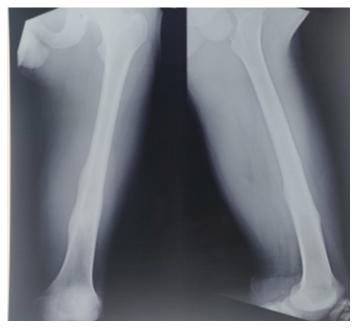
Six weeks follow-up radiograph showing thickening of periosteal reaction
